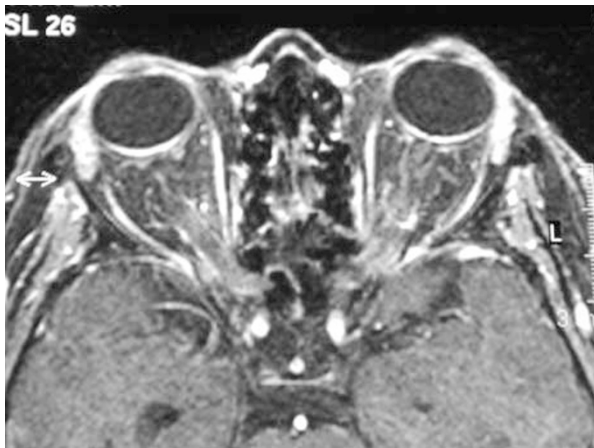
Gadolinium-enhanced axial MRI T1-weighted SPIR demonstrates bilateral slight enhancement of the apical optic sheath.
